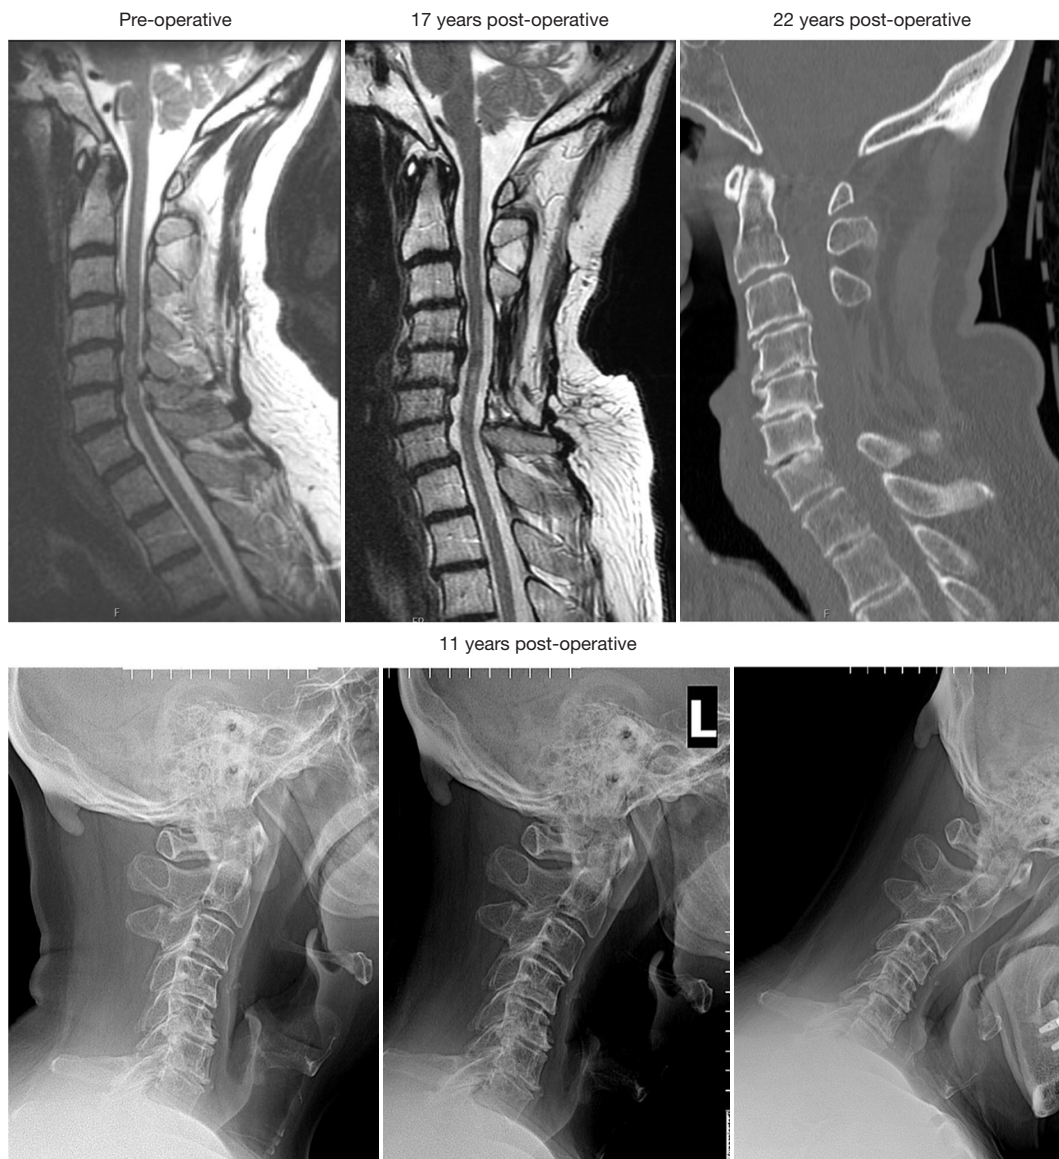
Longitudinal imaging following cervical laminectomy. Preoperative MRI shows multilevel degenerative changes worst from C4 to C6. Patient underwent repeat MRI 17 years post-op to evaluate upper extremity paresthesias. This showed excellent decompression without development of adjacent level disease. Subsequent CT 22-year post-operatively was obtained for evaluation after a fall. Flexion extension films show straightening of the cervical spine but no abnormal motion. CT, computed tomography; MRI, magnetic resonance imaging.
